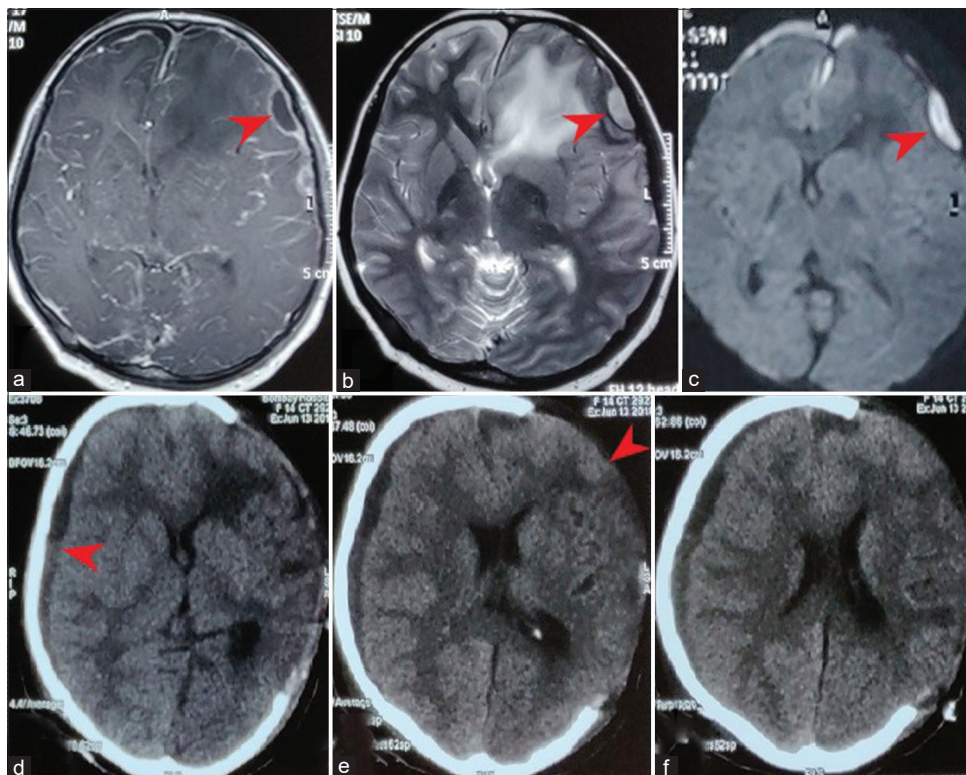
Progression of subdural hematoma to empyema. (a) Contrast-enhanced magnetic resonance imaging T1-weighted image showing left subdural peripherally enhancing collection. (b) T2-weighted image showing cystic collection. (c) DWI showing restriction, suggestive of empyema. (d-f) Post-operative CT scan showing right subdural collection with significant midline shift to the left and herniation of brain parenchyma through the craniotomy defect
